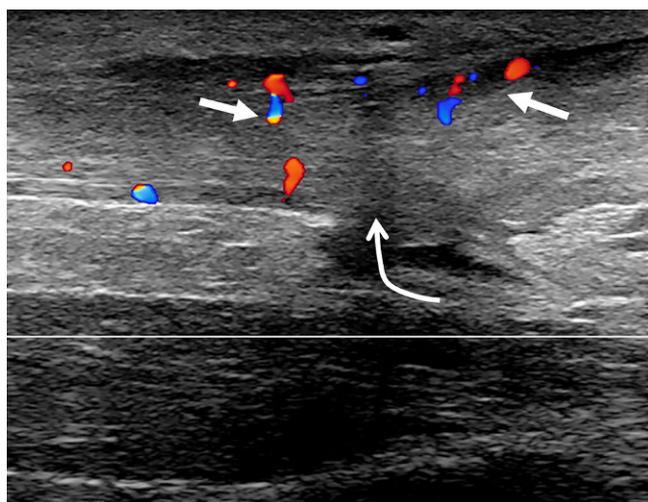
◀ Longitudinal plane color-coded Doppler US image at 3 months showing a slightly hypoechoic tissue with a linear appearance in the area where the tendon stumps join (curved arrow) with decreasing and peripheral vascular flow (arrows)
